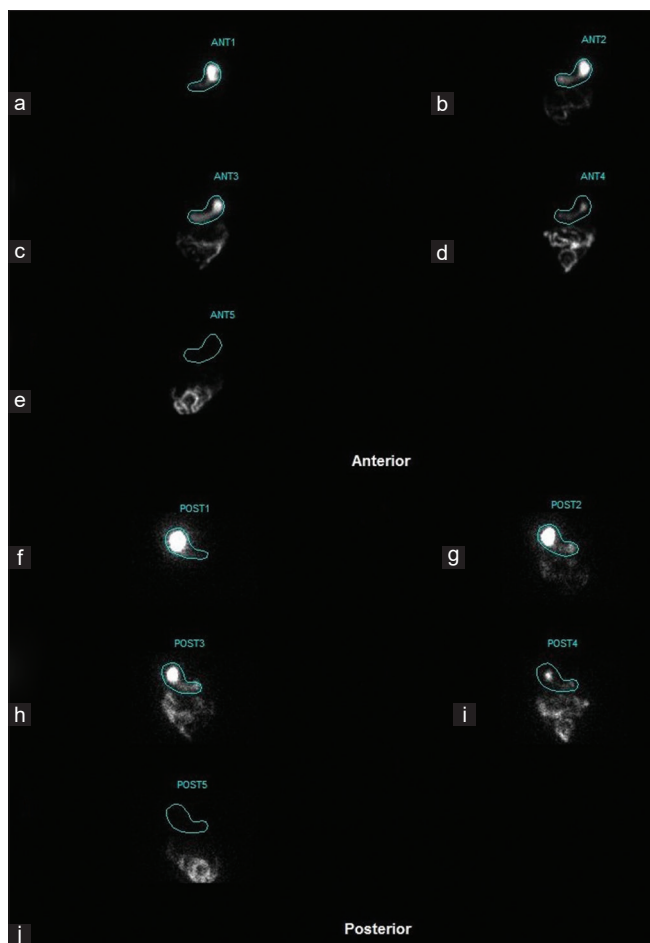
Gastric emptying scintigraphy performed in a 48-year-old female patient of type 2 diabetes mellitus of 7 years' duration. Images were acquired in anterior (a-e) and posterior (f-j) projections after administration of radiolabeled Idli meal immediately, at 30 min, 1 h, 2 h, and 4 h. Entire tracer is seen in the stomach in the first images acquired immediately post meal (a and f) and is gradually noted in the intestines in the images acquired subsequently. Images at 4 h (e and j) correspond to near complete gastric emptying of tracer
